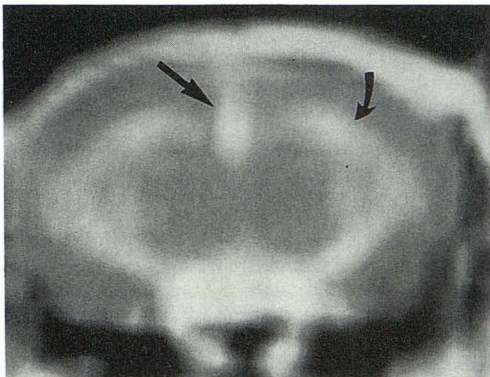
Postcontrast coronal T1-weighted image (800/20) through ventricles 13 days after intracerebral injection of *C. parvum*. Note increased signal of interhemispheric fissure (straight arrow) and bilateral ependymal enhancement of lateral ventricles (curved arrow).
